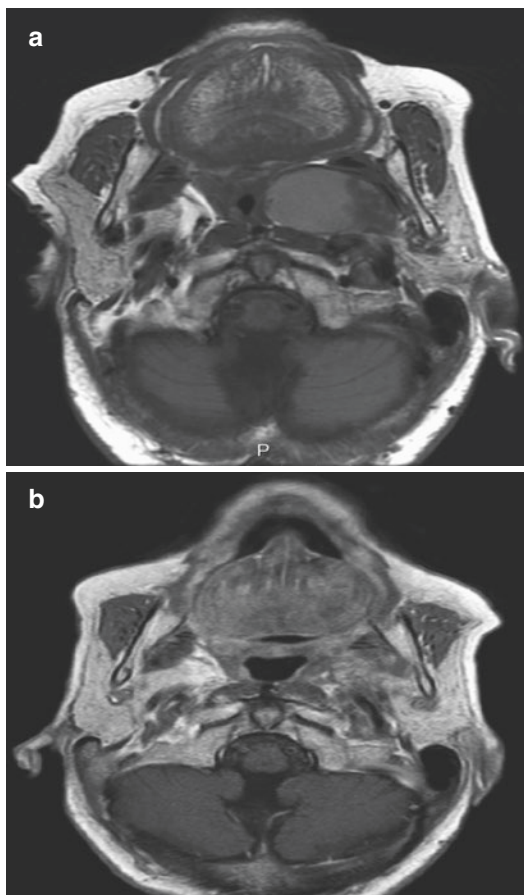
Axial T1-weighted with gadolinium magnetic resonance images of a 78-year-old patient with prestyloid parapharyngeal pleomorphic adenoma; (a) preoperative, (b) 2 months postoperative
